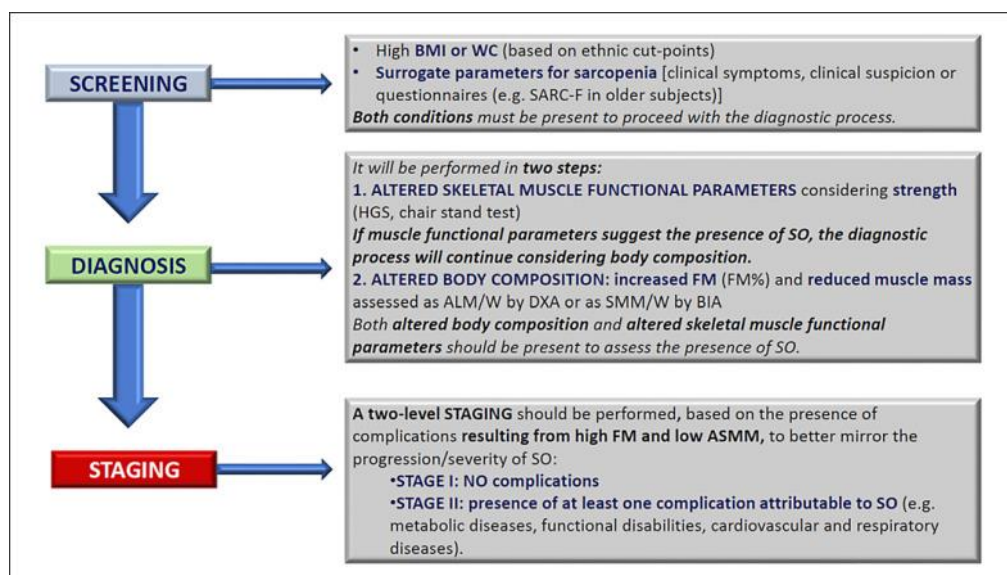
14: Diagnostic procedure for detecting sarcopenic obesity. Abbreviations: BMI: Body Mass Index; WC: Waist Circumference, SARC-F: Strength, Assistance with walking, Rising from a chair, Climbing stairs and falls; HGS: Handgrip Strength; SO: Sarcopenic Obesity; FM: Fat mass; ALM/W: Appendicular Lean Mass normalized for Body Weight; DXA: Dual Energy X-Ray Absorptiometry; SMM/W: Total Skeletal Muscle Mass normalized for Body Weight; BIA:
